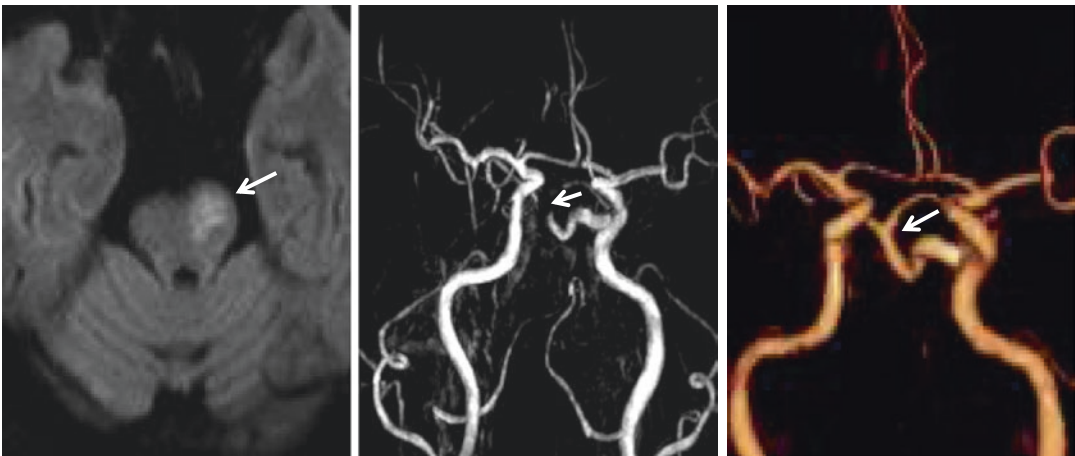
A 70-year-old man with atrial fibrillation developed dysarthria and right hemiparesis. Brain CT did not show hemorrhages. While he received intravenous rt-PA, diffusion-weighted MRI and MRA were performed that showed a left pontine infarction (arrow, left image) and embolic occlusion of the persistent trigeminal artery (PTA) (arrow, middle image). Basilar artery (BA) and distal vertebral arteries (VAs) were not well visualized. His
